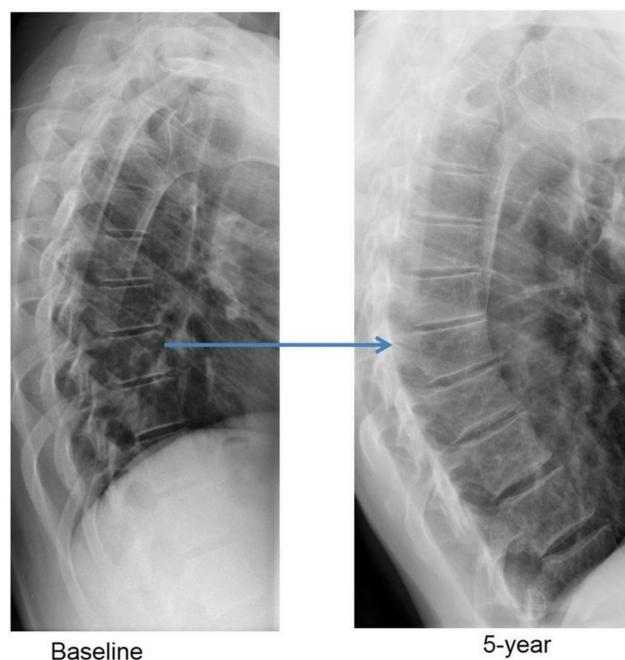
Incident vertebral deformity on spine radiographs.
